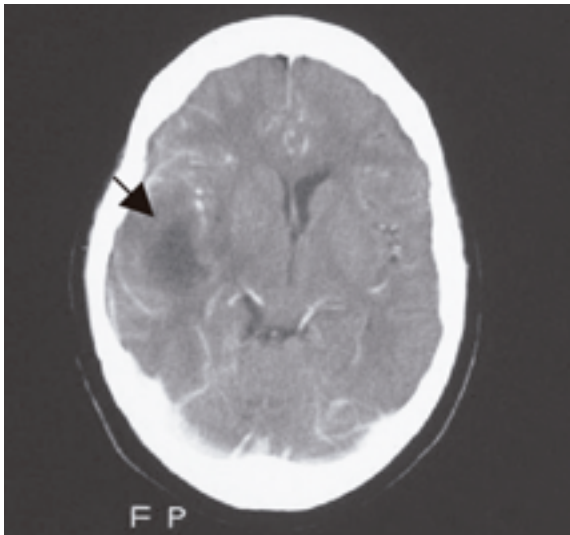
Enhanced axial CT image of the brain shows a large right temporal lobe rim-enhancing abscess (arrow) with mass effect.
